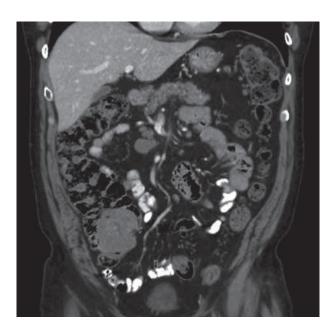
Computed tomography of the abdomen showing a large mass at the ileocaecal area.
